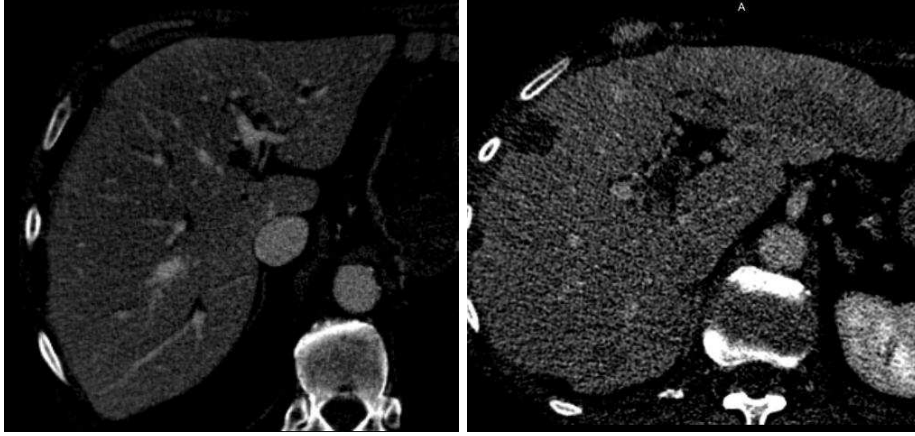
(Left) CTA image of a normal liver (120kV-310 mAs), CNR = 16.2 dB; (right) noisy CTA image of a cirrhotic liver (100kV-140 mAs): CNR = 2.8 dB.
